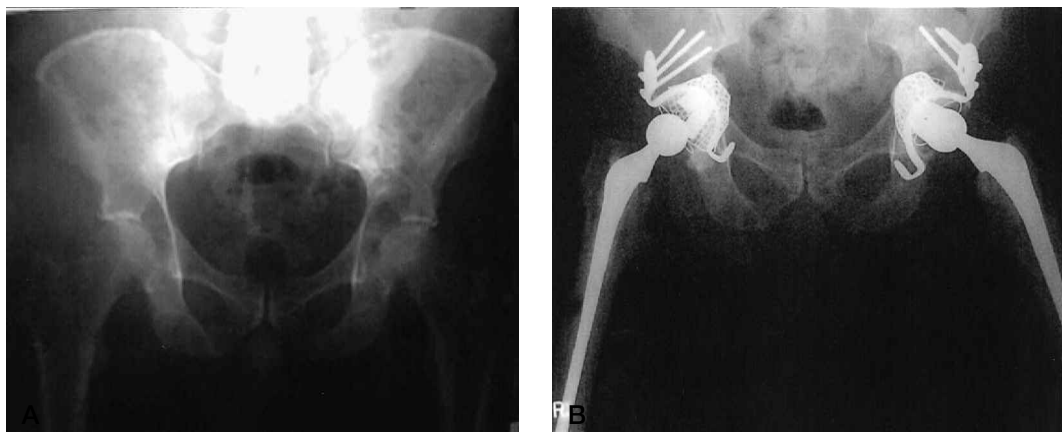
Bilateral procedure in patient with bilateral class III lesions (53-year-old man with metastatic renal carcinoma). (A) Preoperative and (B) postoperative radiographs.
